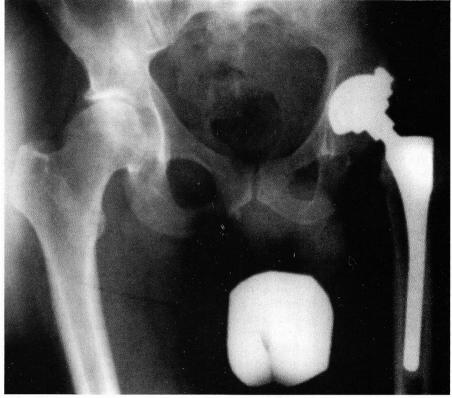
AP X-ray of the pelvis of a 42 year old male with the history of a left hip fracture status-post pinning and subsequent osteotomy as an adolescent. The patient underwent left total hip arthroplasty in 1990, and presented with clinical and radiological evidence of loosening of his cementless components.
